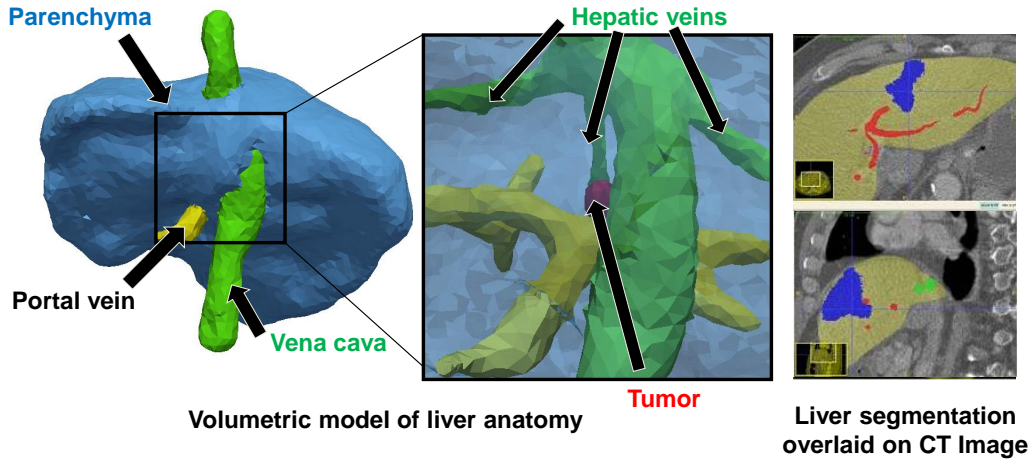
A detailed anatomical model of the liver is estimated from a standard clinical CT image. *See text for details.*
